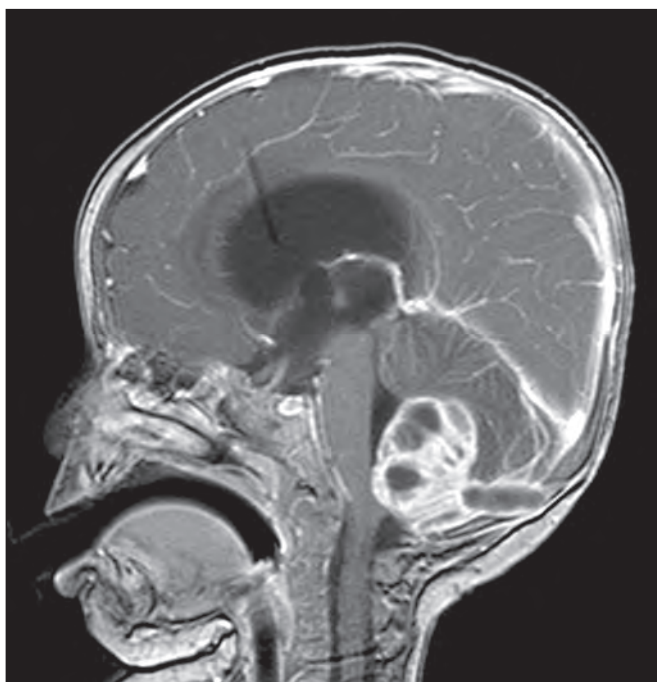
Sagittal MRI section showing a cerebellar mass lesion communicating subcutaneously through the occipital bone defect.
